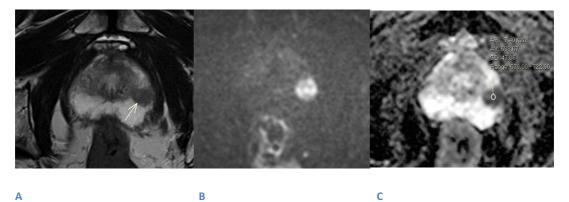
Axial T2 (A), high B-value DWI (B) and ADC map (C) image of prostate. Lesion of high suspicion of being clinically significant cancer (white arrow). The lesion is of low signal on T2 with corresponding high signal on high b-value image and signal drop on the calculated ADC map
